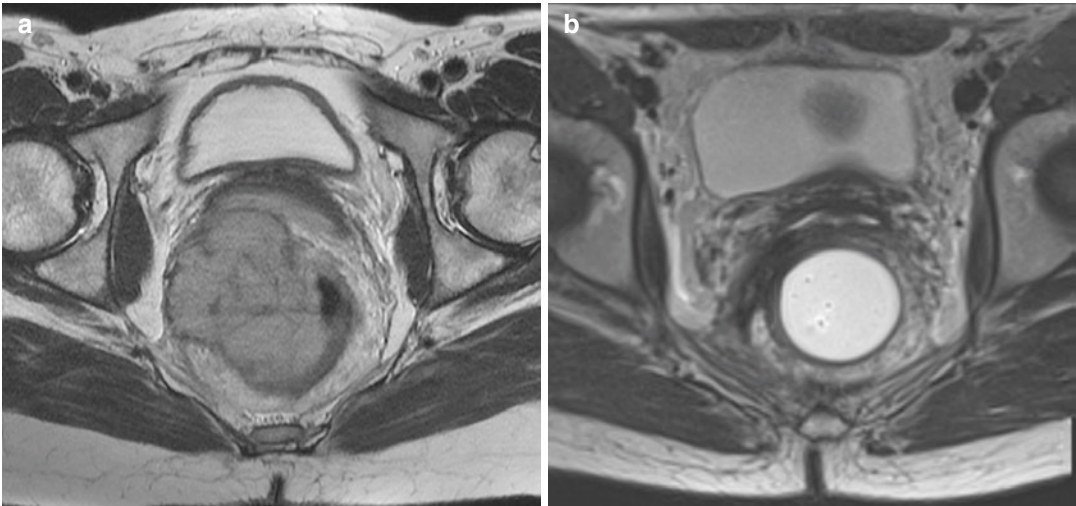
A patient with rectal squamous cell cancer. (a) Initial T2-weighted axial MR image shows a large mass of intermediate signal intensity abutting the mesorectal fascia, posterior vaginal wall, and right levator muscle. (b) T2-weighted axial MR image performed 3 months after chemotherapy (5-FU and mitomycin) and radiation therapy
